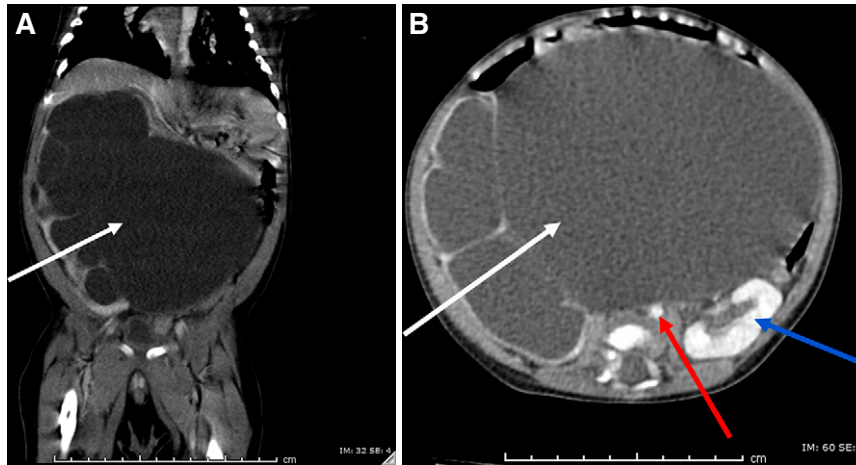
Abdominal computed tomography (CT) scan shows massive hydronephrosis. (A) The patient's abdominal CT scan in the coronal plane showing the right kidney parenchyma stretched over the massively dilated central collecting system (white arrow), which occupies the majority of the abdomen. (B) The patient's abdominal computed tomography scan in the axial plane showing the right kidney parenchyma stretched over the massively dilated central collecting system (white arrow). There is a profound mass effect on abdominal organs, including the left kidney (blue arrow), vessels, and bowel, specifically compressing and displacing the aorta (red arrow) and inferior vena cava.
